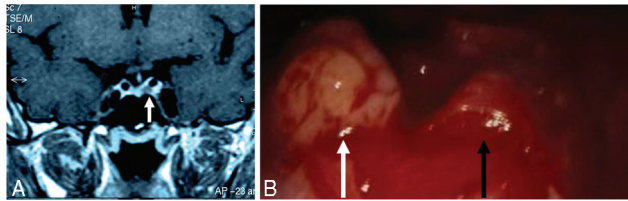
(A) T1-weighted magnetic resonance image of microprolactinoma in the left side of pituitary gland (white arrow); microadenoma appears hypointense in the context of pituitary gland. (B) Intraoperative microsurgical view of the same prolactinoma of (A) (white arrow), well distinguished from the pituitary gland (black arrow).
